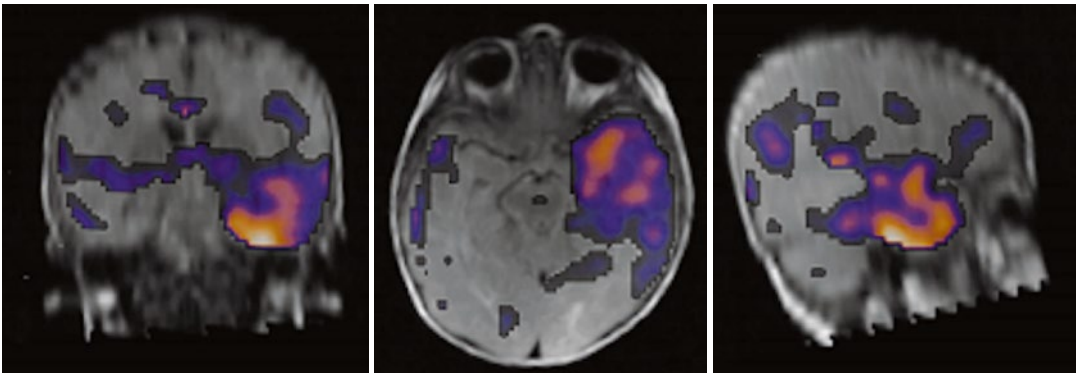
Single photon emission computed tomography (SPECT) and magnetic resonance imaging (MRI) image fusion in a patient with intractable seizures. Ictal minus
